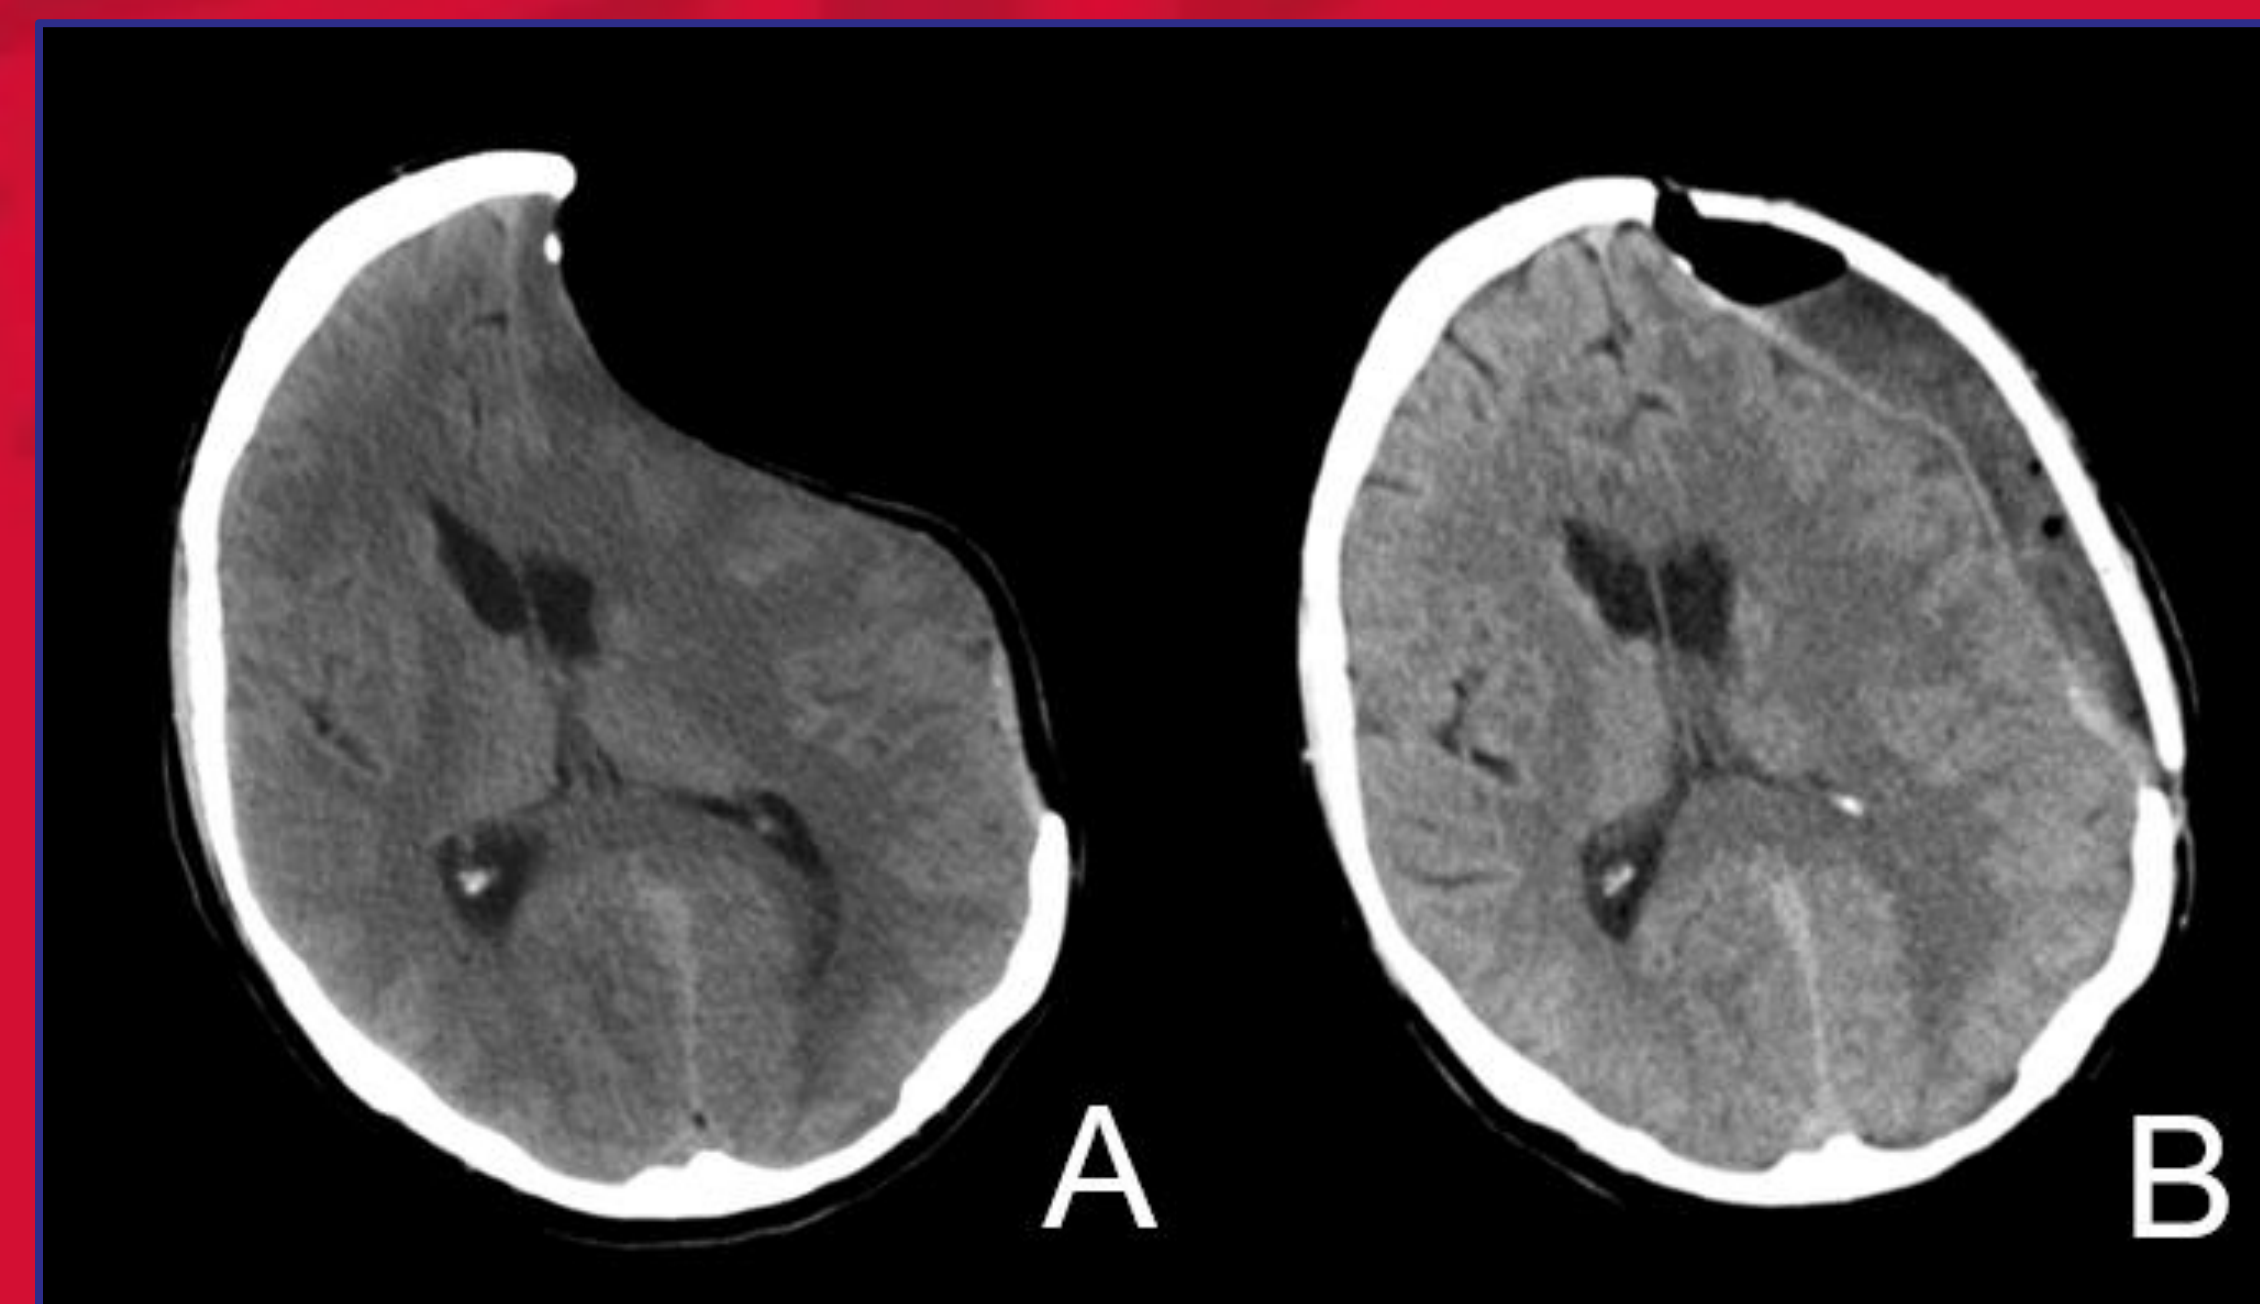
Computed tomography of the head without contrast, axial images for case one. A) Performed on day 45 after left hemi-craniectomy showing sulcal effacement, mass effect of the left frontal lobe with paradoxical rightward midline shift of approximately 14mm. B) Performed 18 days after cranioplasty, showing a 5mm midline shift and fluid accumulation deep to the bone flap in the left frontotemporal extra-axial space.
